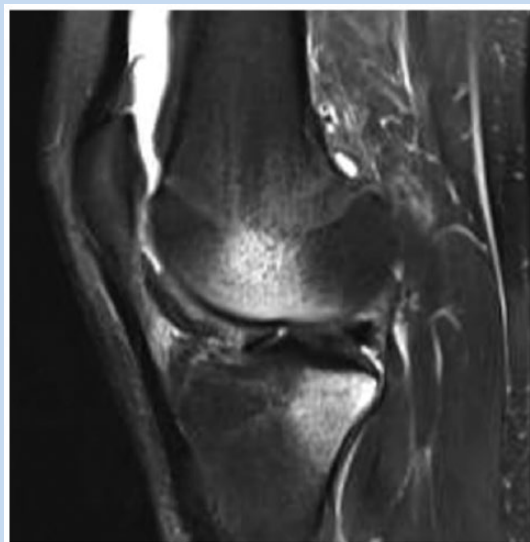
Anterior cruciate ligament rupture. T2-weighted sagittal magnetic resonance image demonstrating the bony edema pattern on the lateral femoral condyle and lateral tibial plateau characteristic of an acute anterior cruciate ligament injury.
